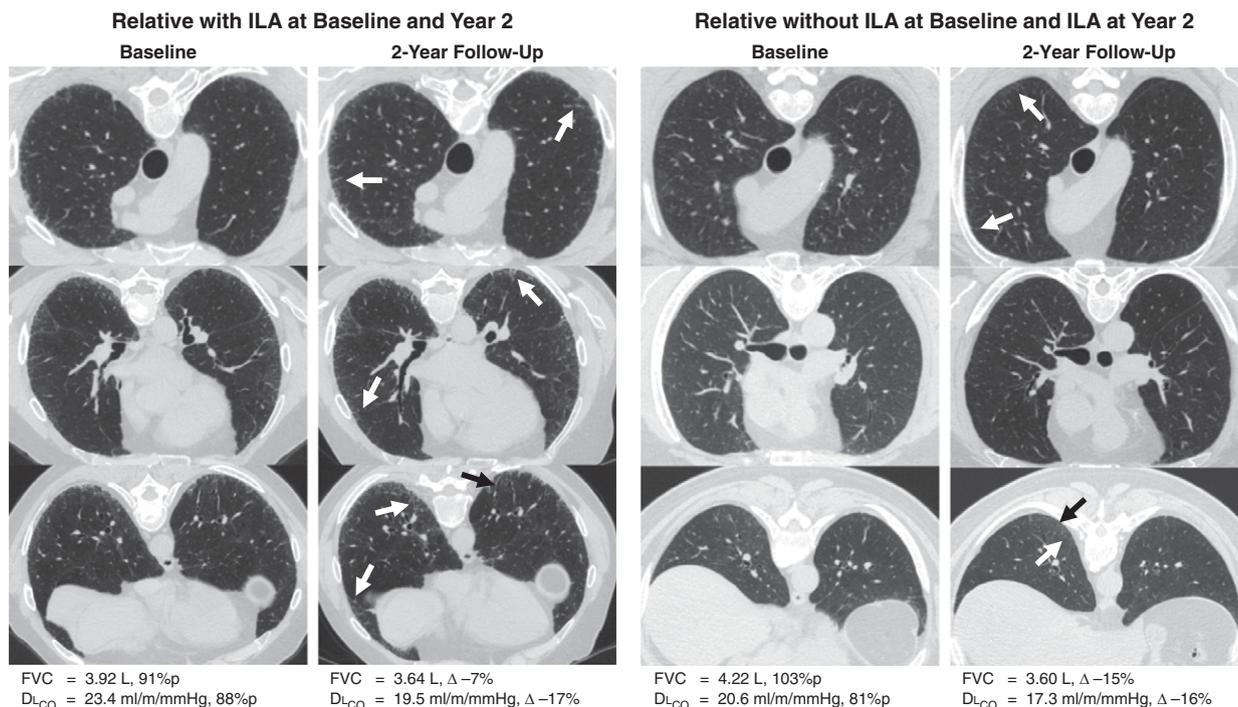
Computed tomography scans of the chest from two relatives with interstitial lung abnormalities (ILA) and progression at the 2-year follow-up. The first participant with ILA at baseline and 2-year follow-up had radiologic progression, including worsening reticulations throughout the lungs (white arrows) and increased basilar traction bronchiolectasis (black arrow). At the 2-year follow-up, FVC had decreased by 7% and DL_{CO} by 17%. The second participant was indeterminate for ILA at baseline but had ILA at the 2-year follow-up and radiologic progression, including new and increased areas of upper lobe and basilar reticulation (white arrows) as well as new basilar traction bronchiolectasis (black arrow). At the 2-year follow-up, FVC had decreased by 15% and DL_{CO} by 16%.
